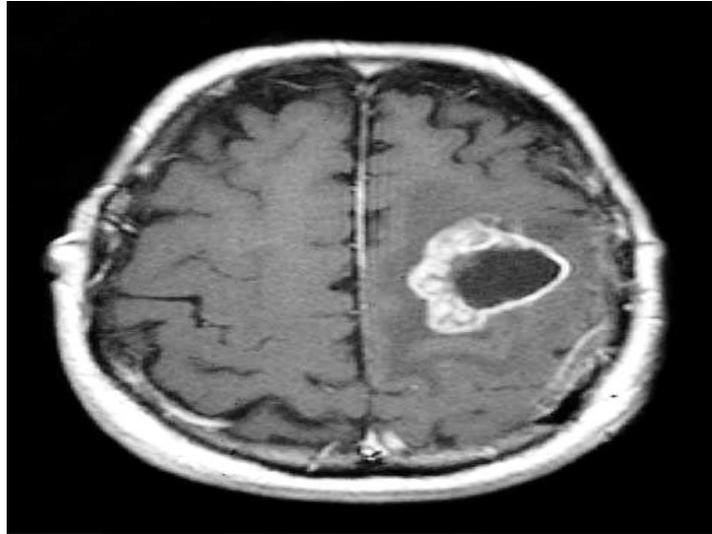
MRI of a Glioblastoma Multiforme in the Left Frontal Lobe, Obtained after the Administration of Gadolinium. The tumor is characterized by the irregular enhancing margin with central necrosis (DeAngelis 2001).
